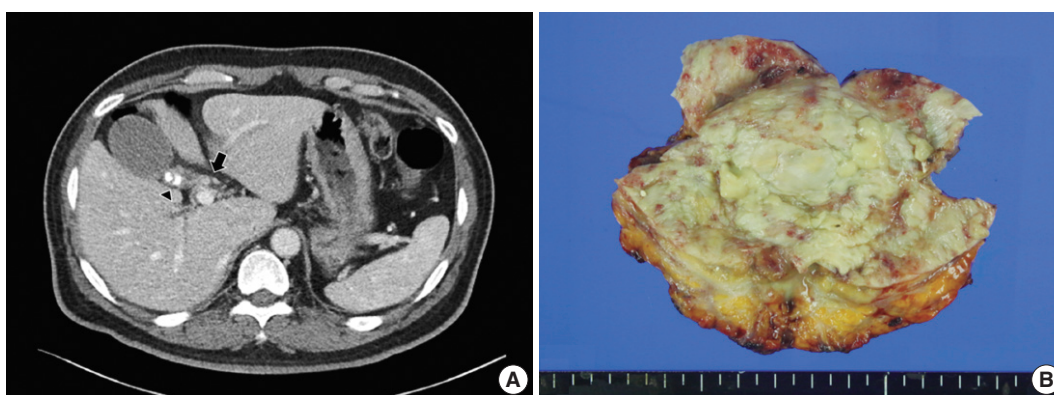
Computed tomography and gross findings of hyalinizing cholecystitis and associated carcinoma. (A) Biliary computed tomography scan reveals subtle enhancement of wall thickening at the confluence of the cystic duct and the common hepatic duct (arrow). There is mild wall thickening of the gallbladder with multiple calcified gallstones in the neck portion (arrowhead). (B) Grossly, the gallbladder wall shows diffuse fibrosis and is covered by yellowish necrotic materials, without mass-like lesions.
